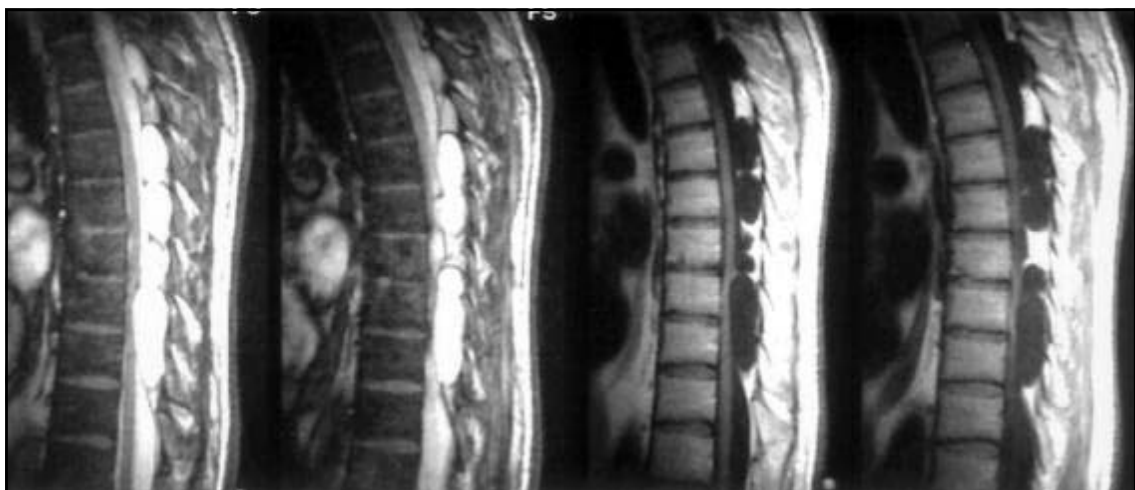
MRI Sagittal T2WI and Sagittal T1WI: Multiple cystic lesions in extra dural situation.
